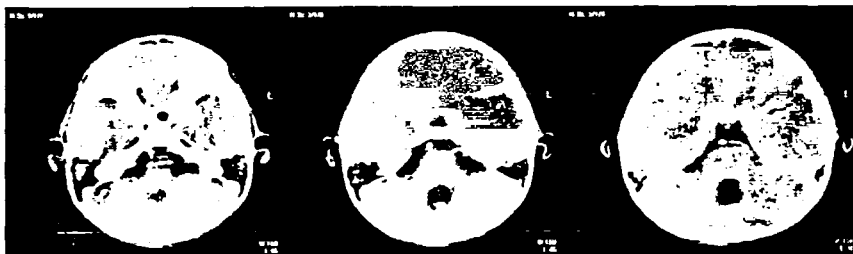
Preoperative, precontrast, serial CT scan axial images in patient R. V. I.
